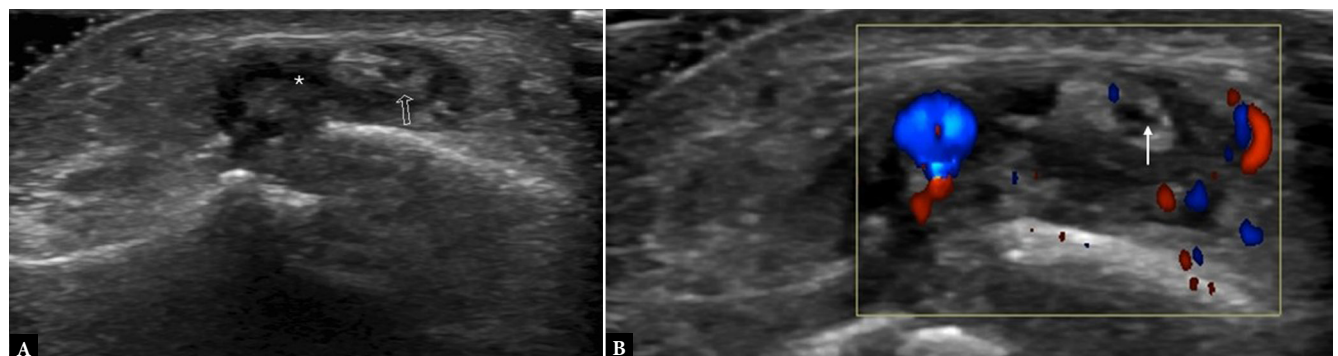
A 67-year-old woman with a small painful palpable lump at the dorsal foot causing numbness of the big toe during pressure from shoes and walking. A. Diagnostic US showed hypoechoic tissue (asterisk) around the medial branch of the deep peroneal nerve (arrow), located just lateral to the dorsalis pedis artery in close relation to the navicular–medial cuneiform joint. B. Note the enlarged hypoechoic fascicles (arrow) and surrounding intensely echogenic connective tissue, the artery visualized on color Doppler and the hypoechoic tissue between them. Impingement of the nerve by the hypoechoic tissue was suspected and reported. The surgeon asked for a diagnostic nerve block before deciding on surgical management. Using a 23-G needle, an injection of a long-lasting anesthetic (ropivacaine) was performed with a high-resolution 18 MHz hockey-stick probe. Following relief of symptoms for a few hours, surgical debridement of the nerve was performed
